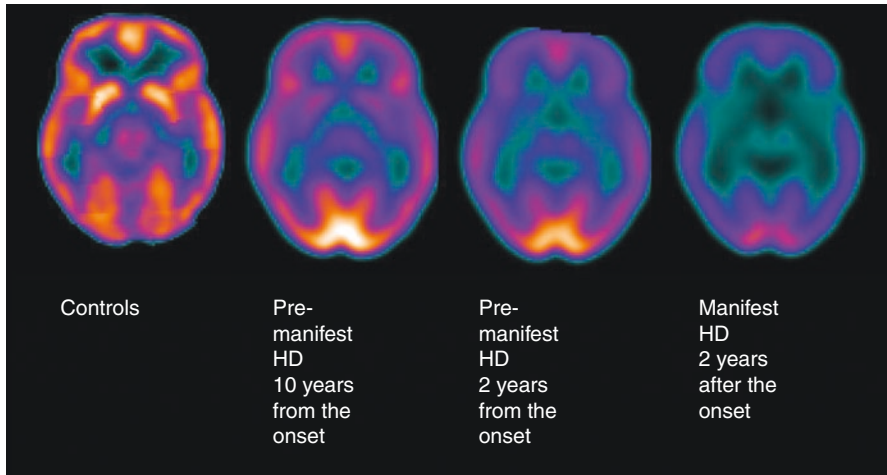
Representative [^{18}F]FDG-PET/CT images at different stages of Huntington's disease. Courtesy of Prof. Andrea Ciarmiello, Nuclear Medicine, S. Andrea Hospital, La Spezia, Italy
